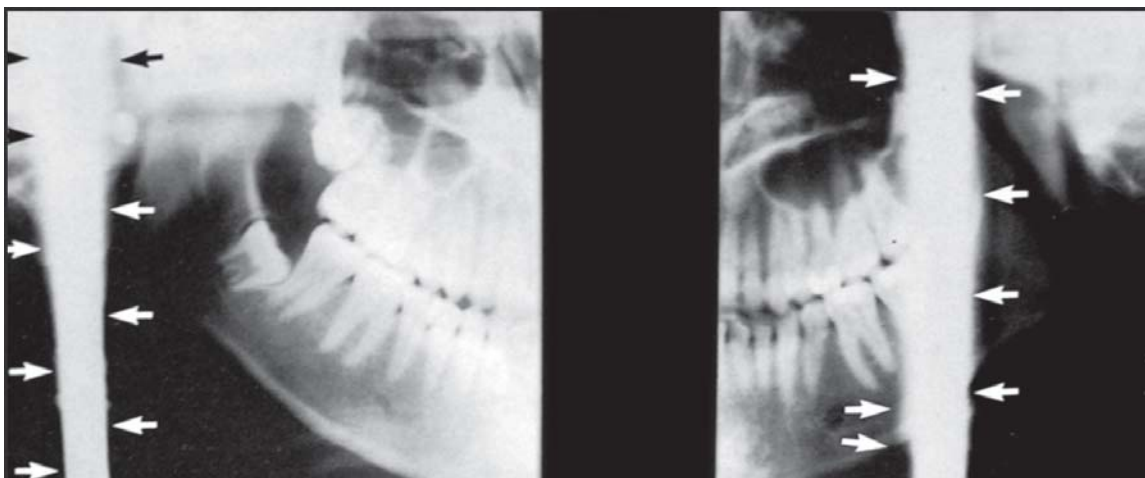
White vertical bands appearing on processed panorex radiograph as a result of accidentally releasing the exposure switch and then pressing down for the remainder of excursion
